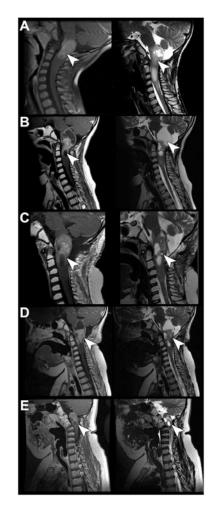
Biopsy proven pseudoprogression of a cervical medullary anaplastic astrocytoma 4.5-year-old with a biopsy-proven cervicomedullary anaplastic glioma (top row baseline) who developed worsening neck pain after his 4th vaccine, which became increasingly severe immediately after his fifth vaccine, 6.5 months after diagnosis, 4 months after completion of irradiation and 3 months after beginning vaccination. He exhibited neurological worsening and MRI showed formation of a necrotic cyst superior to the tumor in the medullary region (second row). Vaccines were withheld, and the cyst continued to increase in size; his neck pain became debilitating and he underwent laminectomy and cyst decompression 2.5 months later (third row). He had rapid clinical improvement and resolution of the cyst on subsequent MRI scan. Biopsies showed no mitotically active tumor, and he resumed vaccine therapy. Six weeks later, he developed clinical and radiographic worsening with recurrence of neck pain. An MRI showed re-accumulation of the cyst and increased enhancement and size of the solid component, which prompted discontinuation of the vaccine regimen (fourth row). He was started on palliative oral chemotherapy and has shown a dramatic clinical improvement over the next 3 months, is back at school and almost completely off steroids. Five years later the patient is still alive with small stable residual lesion (fifth row)
